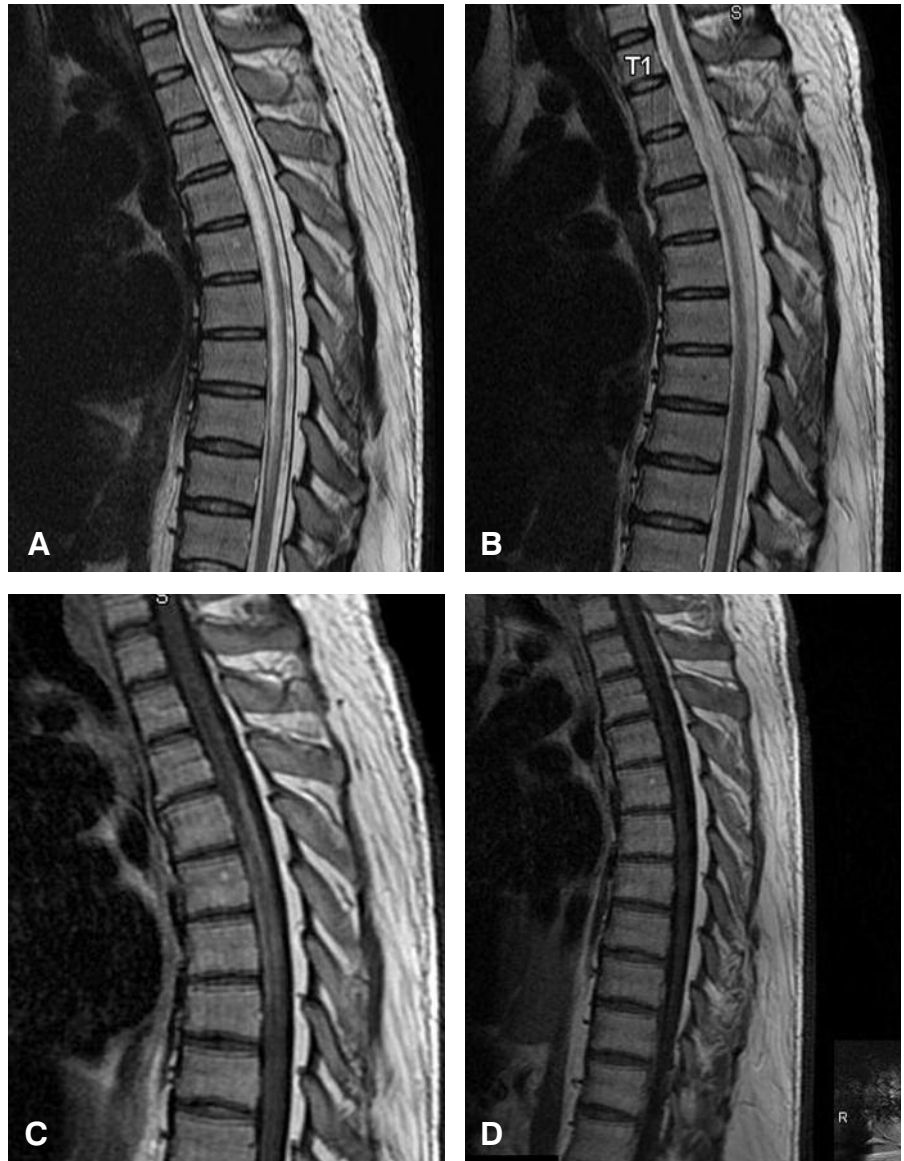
MR images of the thoracic spine show that the acute changes resolved between (A and B) July 2007 and (C and D) October 2007.
